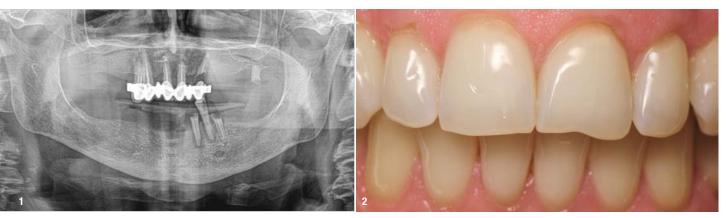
Pre-op panoramic dental radiograph. Fig. 2: Close-up of the patient's granddaughter's teeth.
